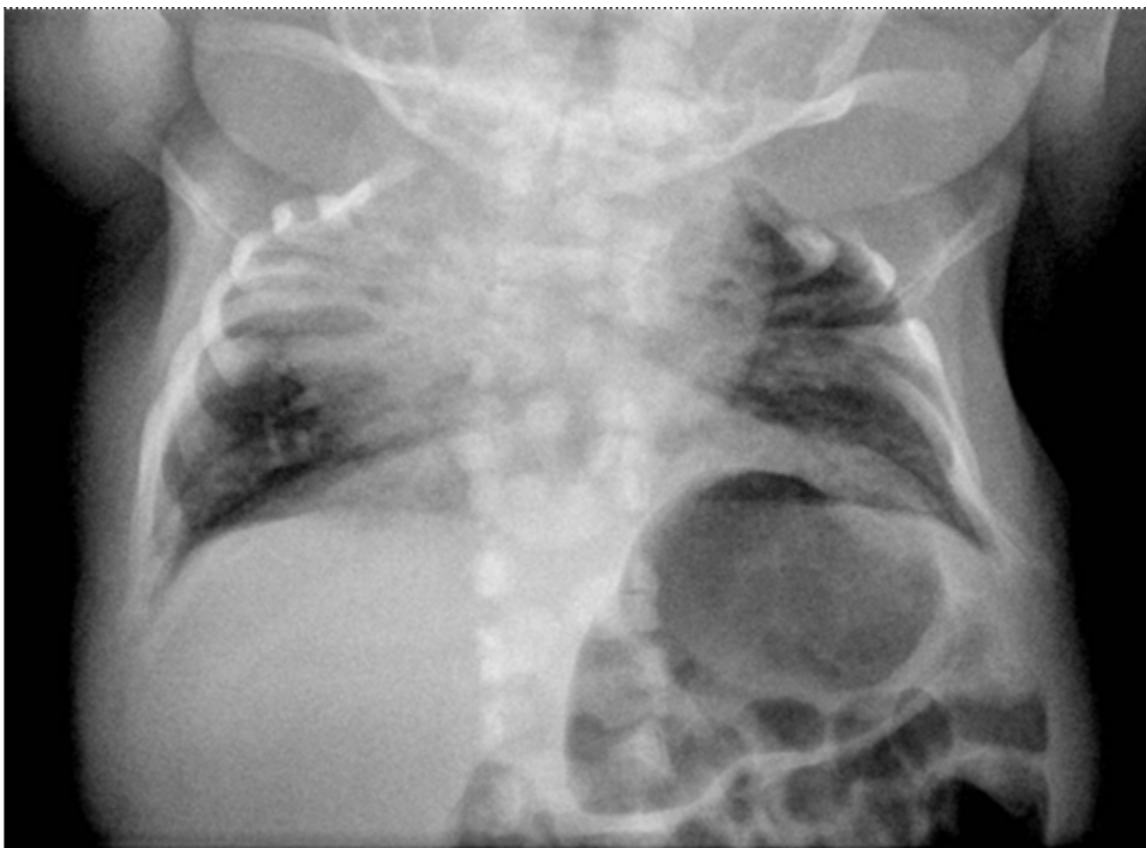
Radiograph of an infant with *MESP2*-related STD. The spine is severely shortened with fusion of the ribs posteriorly at the costovertebral junctions. The ribs fan out in a "crab-like" manner, and in many individuals the ribs show no points of intercostal fusion distal to their posterior origins.
